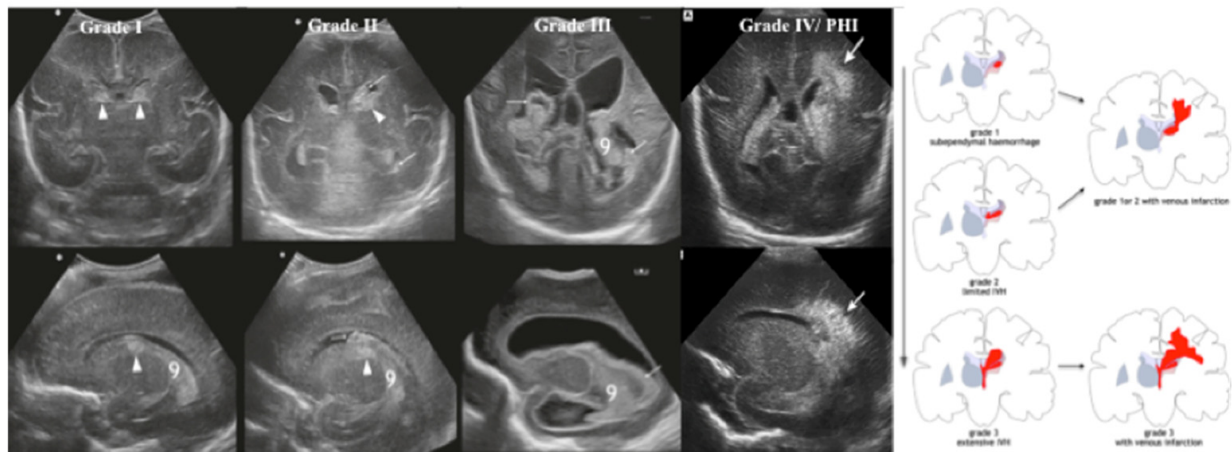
Ultrasound-based IVH grading. Reprinted from "Cranial ultrasound findings in preterm germinal matrix haemorrhage, sequelae and outcome", by Parodi A, Govaert P, Horsch S, Bravo CM, Ramenghi L on behalf of the eurUS.brain group. *Pediatr Res* 2020; 87:13-24. Copyright Springer Nature 2020 (26).
